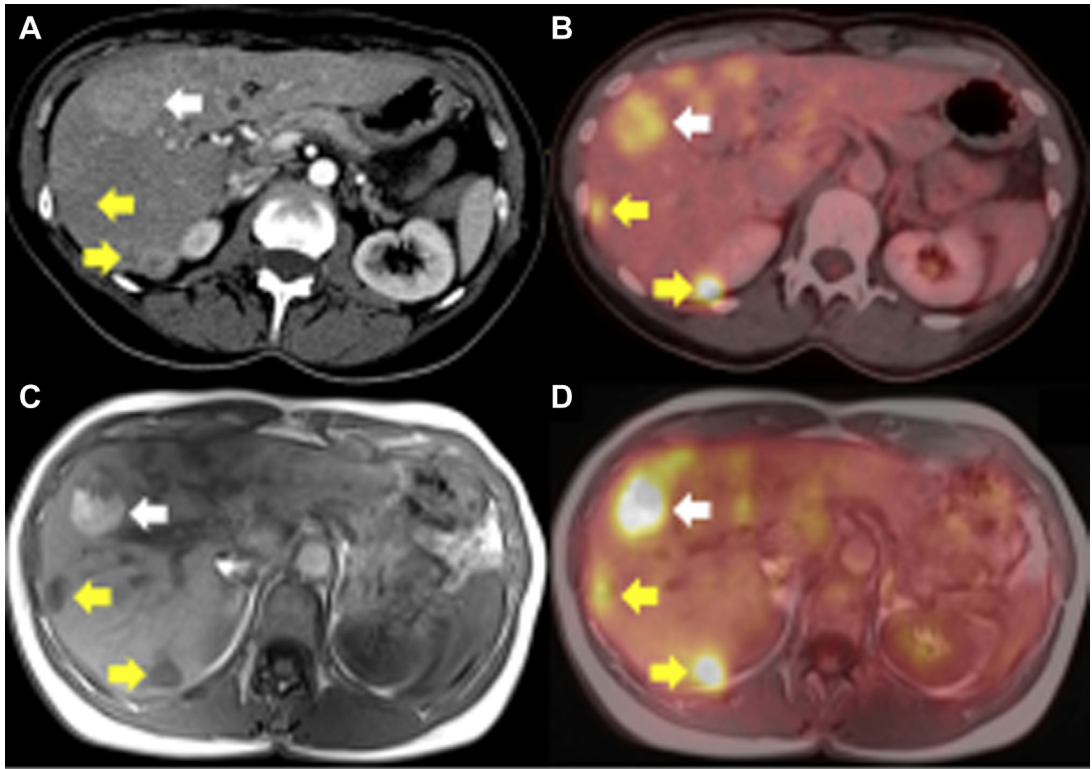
Patient after surgical resection of primary nodular melanoma of the cheek. Contrast-enhanced arterial phase CT (A) and corresponding fused PET/CT images (B); at least 5 hepatic lesions (*white and yellow arrows*) are seen. PET/MRI images (C) also reveal multiple partly hyperintense lesions owing to melanin contact or intralesional hemorrhage (*white arrow*), with a pathologic focal tracer uptake on the PET component of the fused PET/MRI image (D). (From Berzaczy D, Fueger B, Hoeller C, Haug AR, Staudenherz A, Berzaczy G, Weber M, Mayerhoefer ME. Whole-Body [18F]FDG-PET/MRI vs. [18F]FDG-PET/CT in Malignant Melanoma. *Mol Imaging Biol.* 2020 Jun;22(3):739-744; with permission.)
